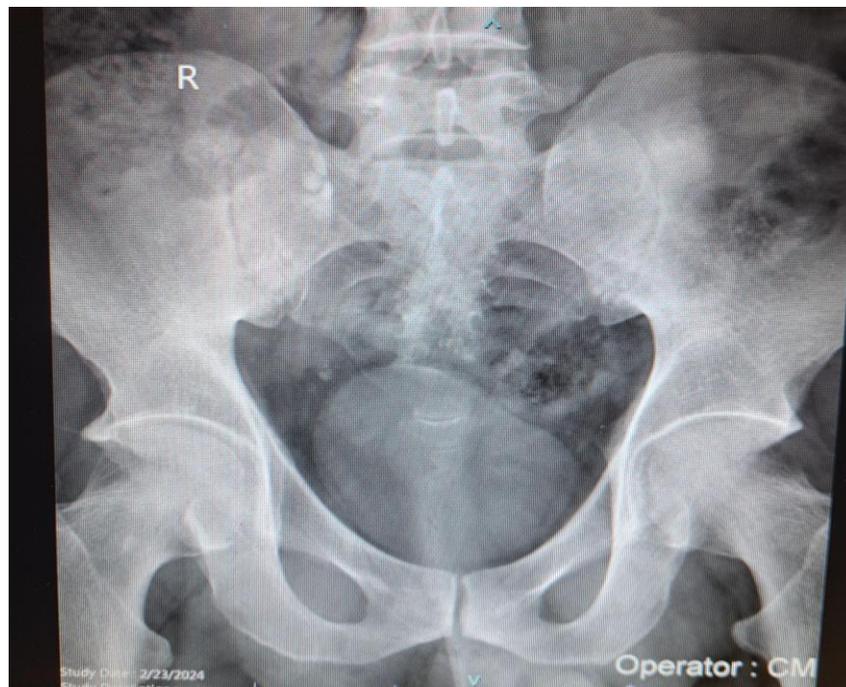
xray kub image showing stones in right ureter
